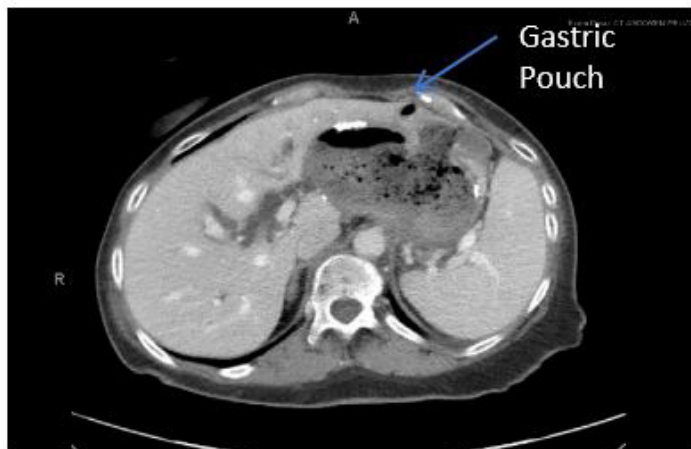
Abdominal CT with IV contrast showing gastric-pouch dilation (axial plane).
